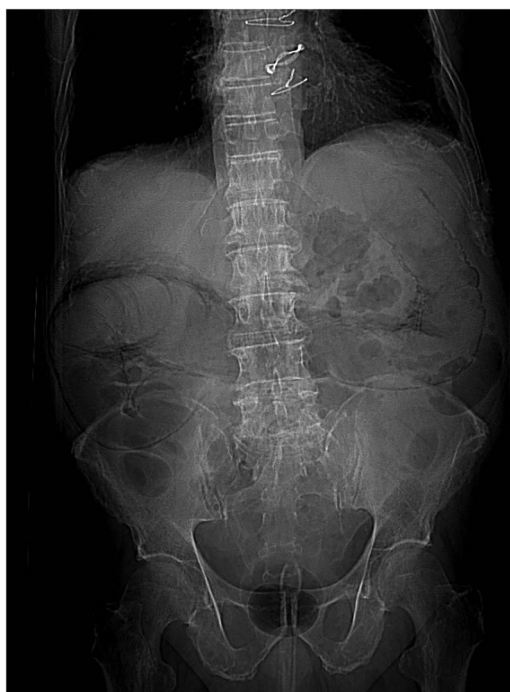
Abdominal X-ray showing signs of pneumatosis intestinalis.
